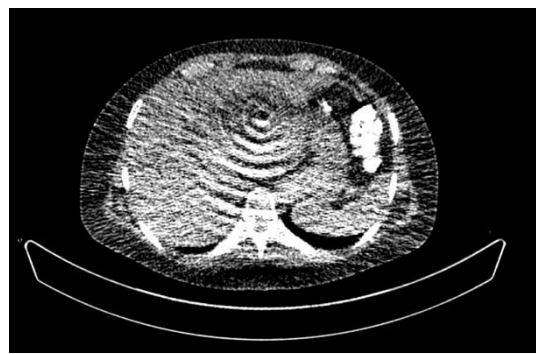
4D CT of the liver made with 30mAs. Ring artefacts are seen.
